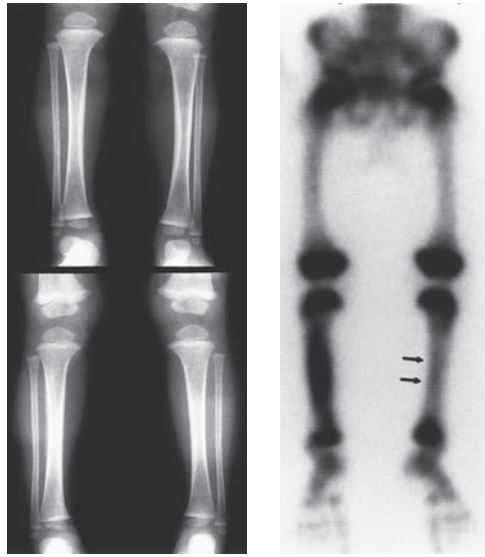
A: Anteroposterior radiograph of the tibia in a 3-year-old child who refused to bear weight on the right leg 3 weeks before presentation. The history of obvious trauma was absent. The radiographs revealed periosteal new bone formation in the midshaft of the right tibia. There was also tenderness to palpation in the left midtibia as well despite normal radiographs. B: A bone scan showed increased uptake in both the left and right tibia. There was significantly less uptake on the left side (arrows) the more recent injury.
